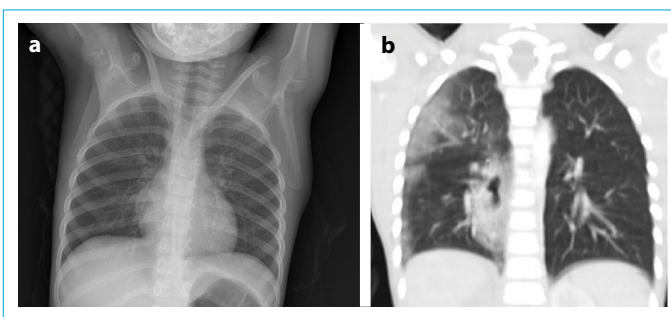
(a) 6 years old boy admitted to the emergency room after trauma. On the chest x-ray (a), ground glass densities are observed in favor of contusion in the right lung upper zone. (b) In the thorax CT, which was taken later, the patient has an incidental cavitory lesion that is not observed by chest radiography.
